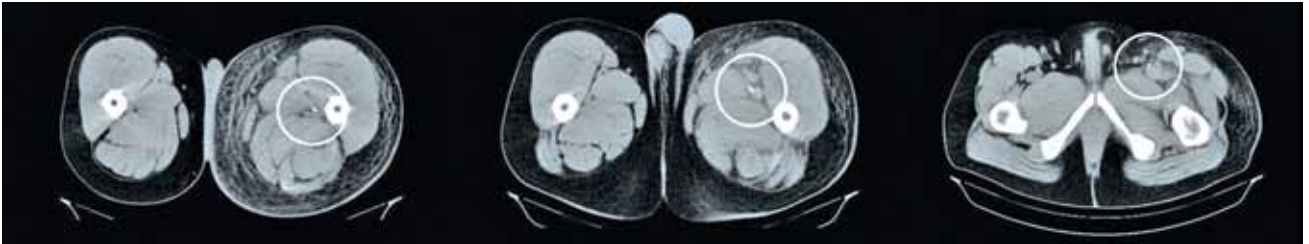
Computed tomography angiography scans showing the upward course of the EKOS EndoWave catheter from the popliteal vein to the common femoral vein. Note the subcutaneous changes of the left leg caused by the edema.
